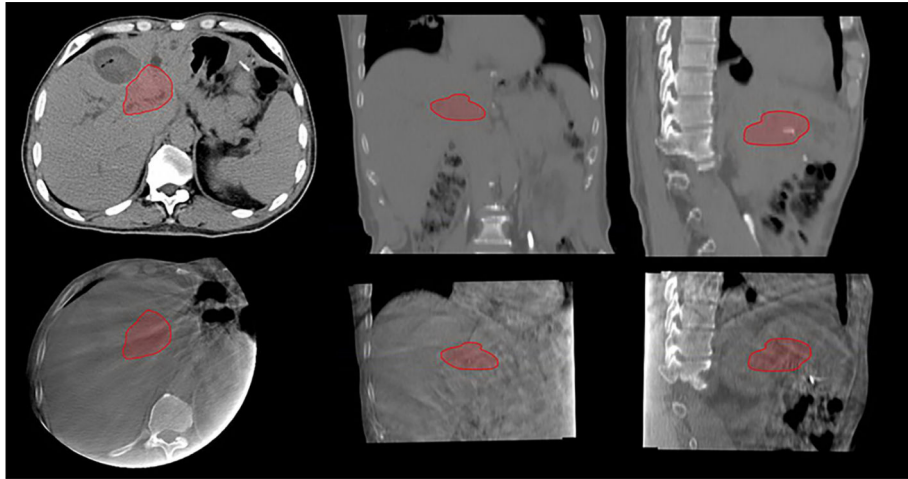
Planning CT (top row) and cone beam CT (bottom row) of a liver tumor in axial, coronal, and sagittal views. Cone beam CT images are of inferior quality with poor visualization of the tumor. Red curve is the contour of the tumor obtained on the planning CT and copied to the Cone beam CT after image registration.
